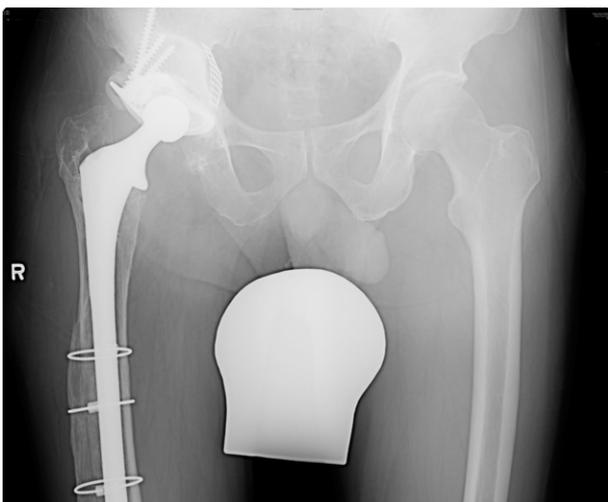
Radiograph showing the post revised right total hip arthroplasty in 2005.
